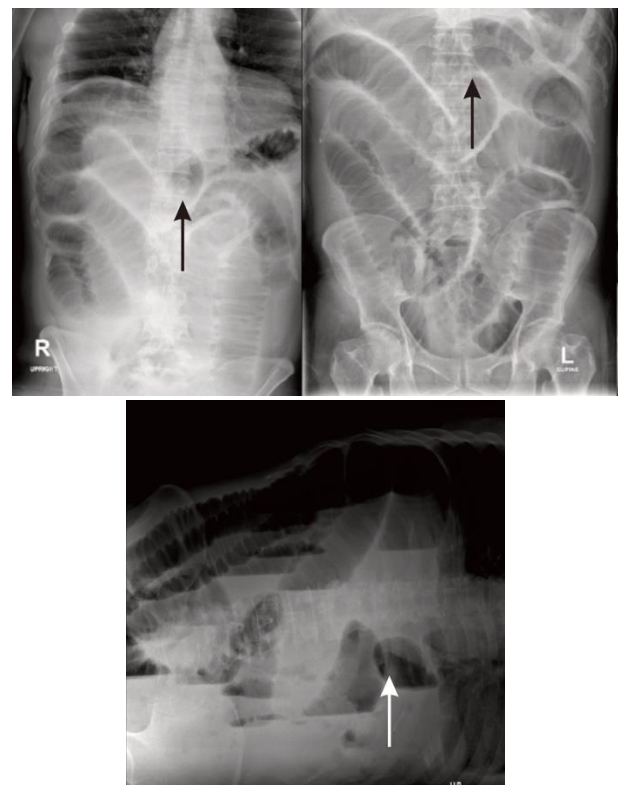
Abdominal x-ray showing bowel obstruction. Arrow shows suspected bowel loop in the lesser sac.
